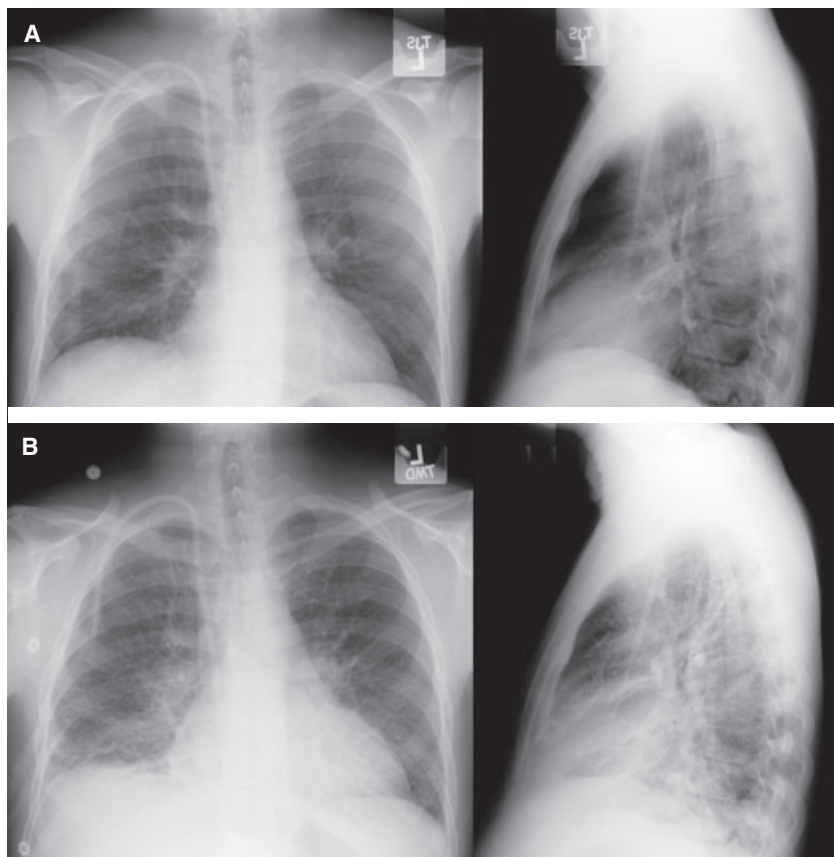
Engraftment syndrome (ES) radiograph findings. (A) Day +8 PBSCT demonstrating relatively normal CXR despite fever and diarrhea. (B) Day +11 PBSCT (same patient) demonstrating increased heart size, diffuse interstitial infiltrates throughout both lungs with alveolar infiltrates in the lower lungs.
